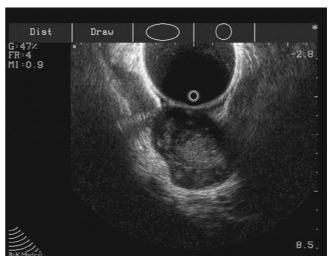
Endoanal ultrasonography showing a large, submucosal lesion, corresponding to a rectal GIST.
